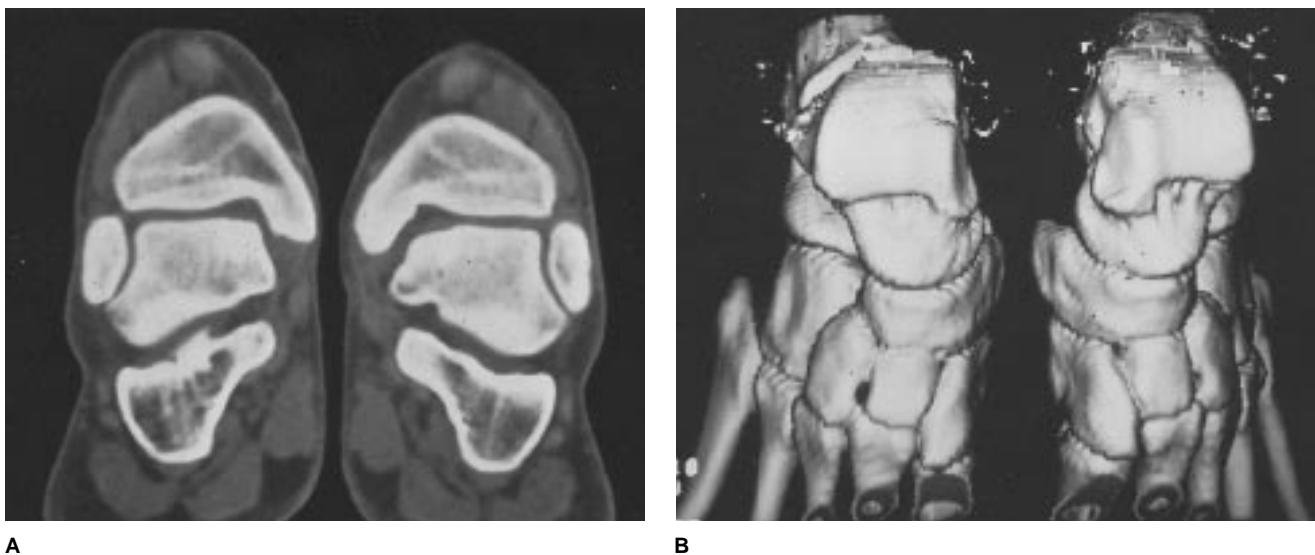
A, Computed tomogram of bilateral medial talar dome osteochondral lesions after arthroscopic debridement. B, Three-dimensional CT reconstruction of same ankle joints.
